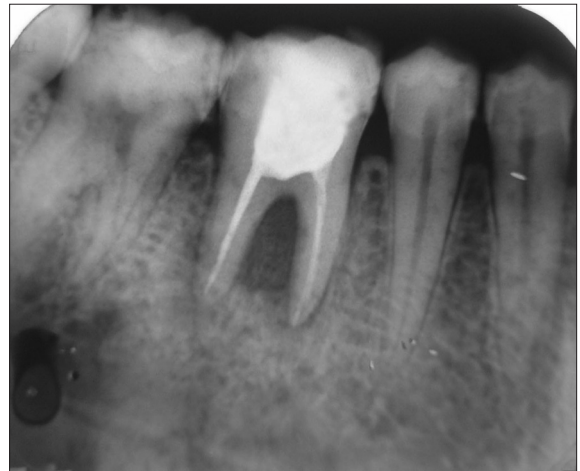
Pre-operative intra oral periapical (IOPA) X-ray
